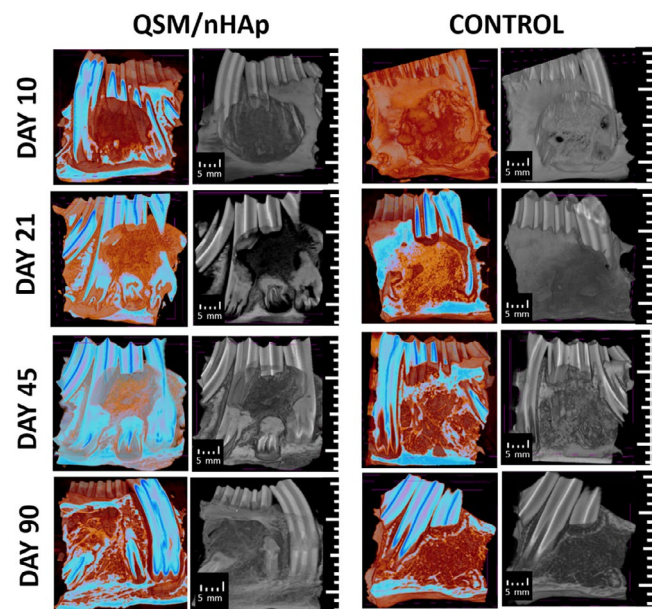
μ -CT images of QSM/nHAp and control samples at days 10, 21, 45, and 90 (scale bar = 5 mm) (blue: high-density mineralized tissue, red: adipose or fibrotic tissue in the defect area or trabecular bone).
